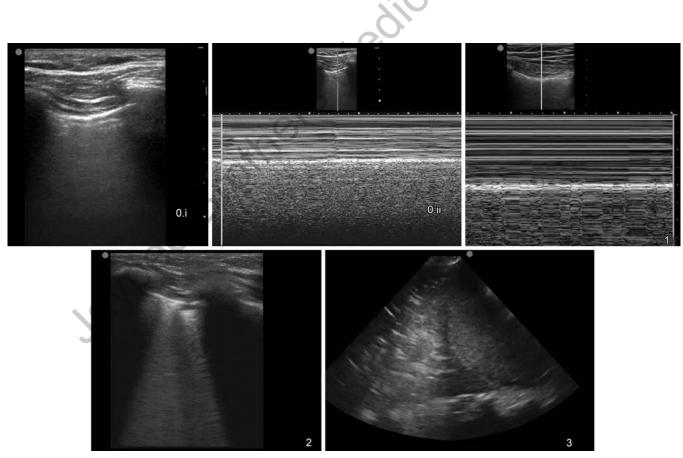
Possible findings at ultrasonographic lung examination. 0: Normal aeration with normal sliding, (i) B mode with A-lines pattern and (ii) M mode showing sea shore sign; 1: M mode showing lung pulse indicating lack of ventilation; 2: B-lines indicating alveolar-interstitial syndrome (AIS); 3: Lung consolidation, hyperechoic area with air-bronchogram.
